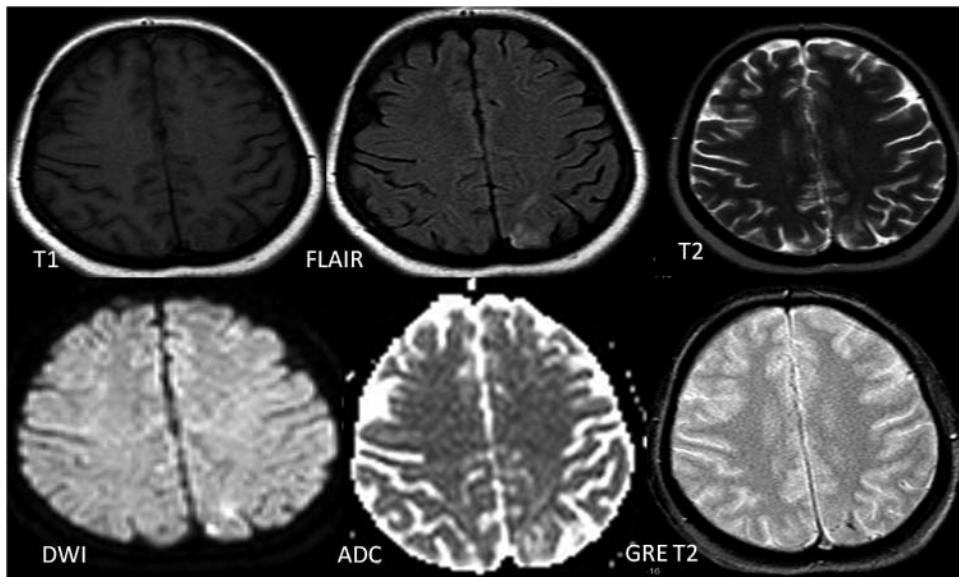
T1, T2 -Weighted and FLAIR images show a region of vasogenic edema involving left occipital cortex and subcortical white matter without restricted diffusion and hemorrhagic transformation on diffusion maps and GRE T2 weighted images, respectively.
